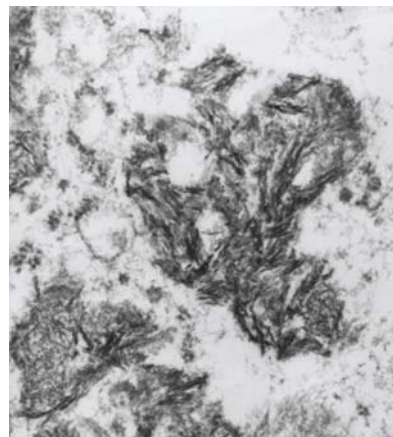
Dense granular material in histiocytes identified by energy-dispersive x-ray microanalysis.
